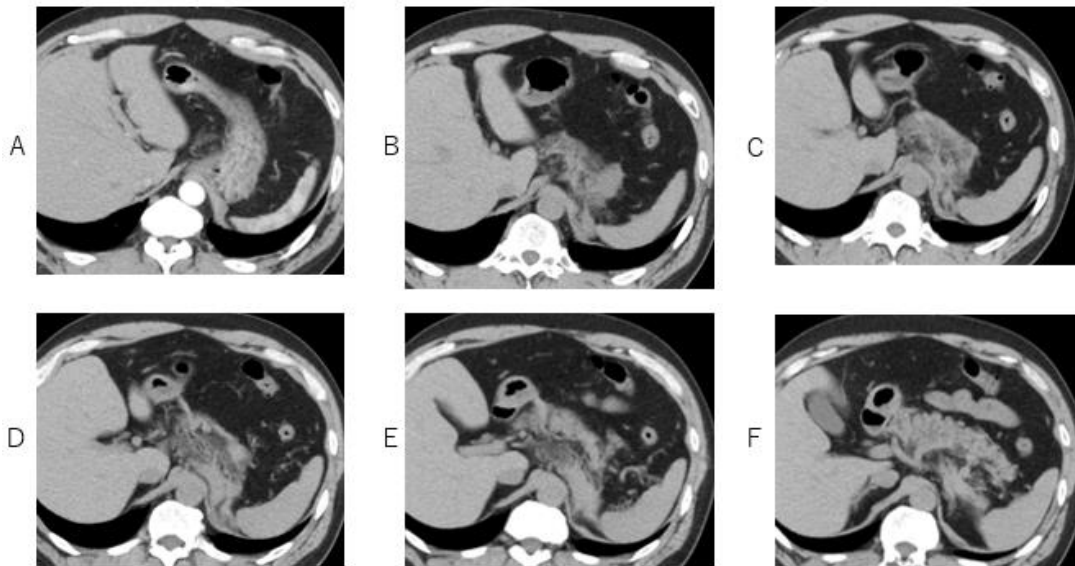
Infiltrative soft attenuation in the mesentery between stomach and diaphragm and between stomach and spleen is depicted on axial CT, suspicious of hemorrhage or inflammation.
